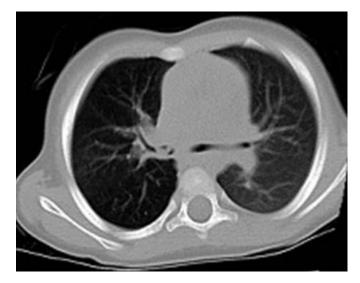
Axial CT section obtained with the parenchyma window; foreign body in the right main bronchus. After bronchoscopy, the object was identified to be a piece of peanut.
